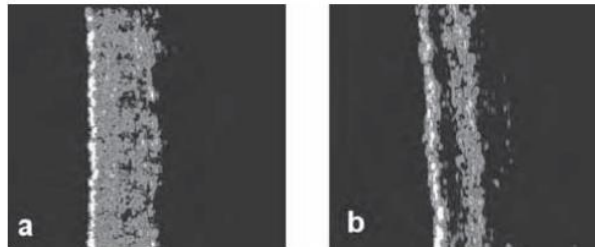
Twenty-megahertz ultrasonographic skin images of the dorsal aspect of the forearm (a) in a young woman (aged 21) and (b) in an elderly woman (aged 83) with marked sun exposure during the lifetime, by JORDEN SERUP, 2006.
